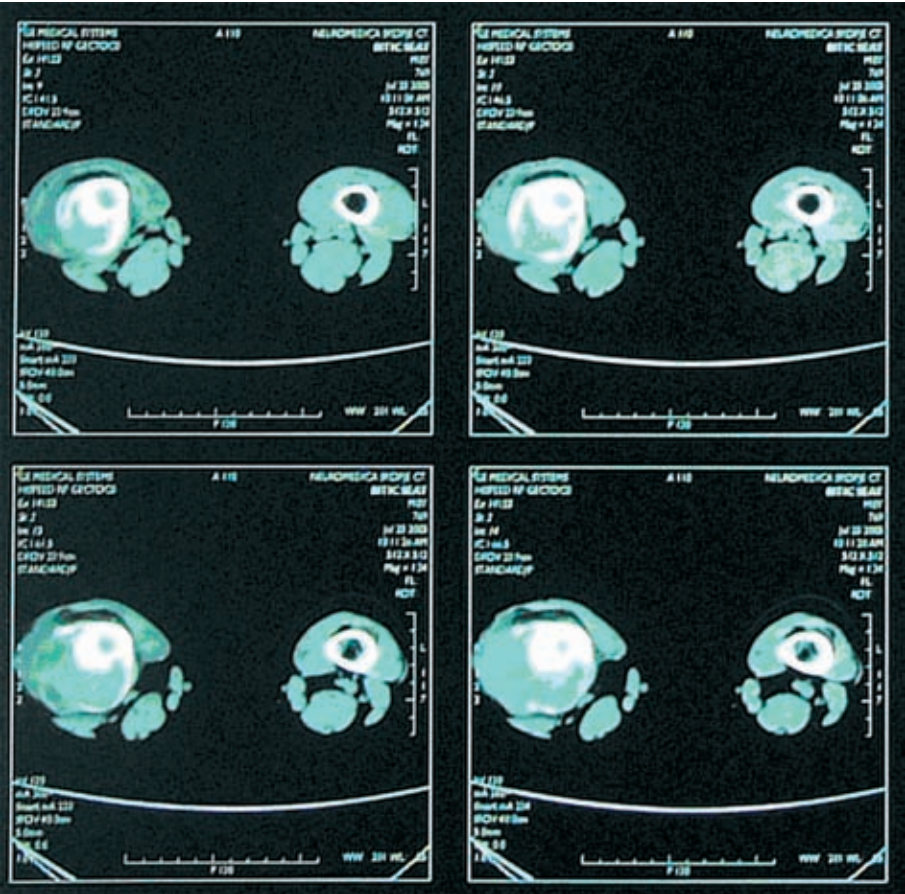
CT of distal femur showing the extent of medullary involvement of the bone (case 3).
